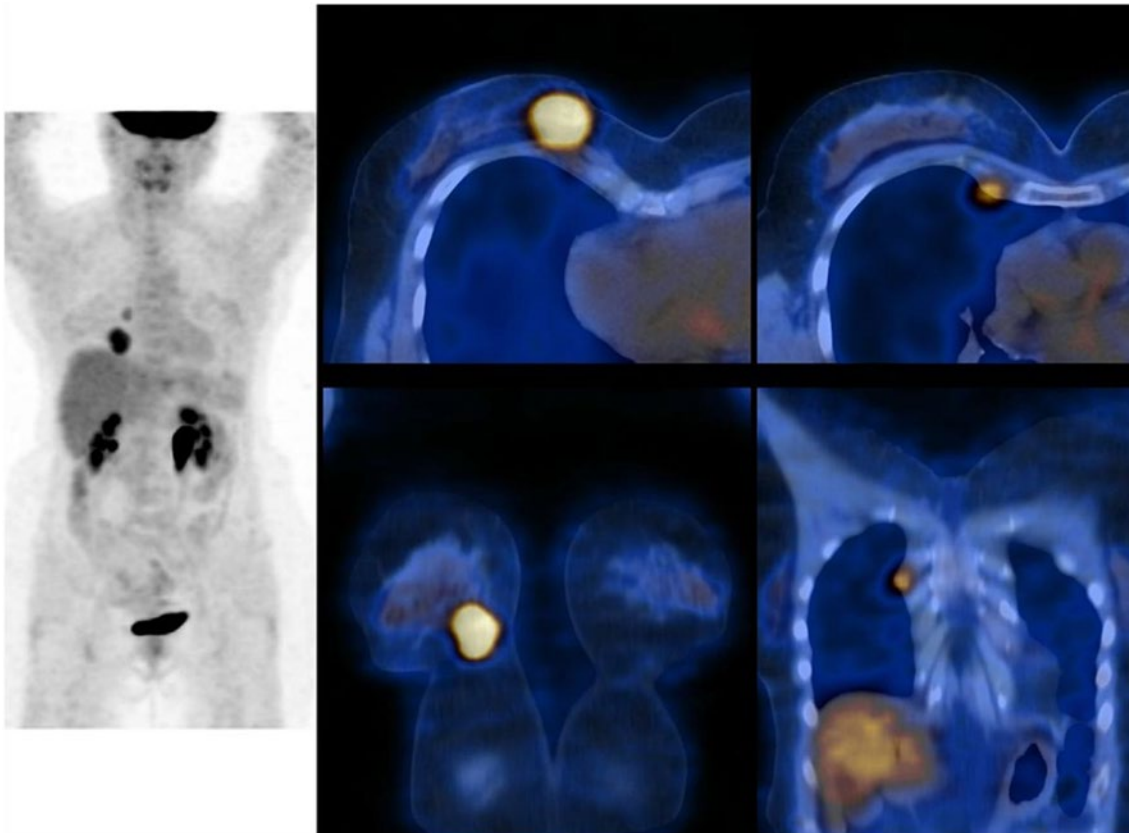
Invasive ductal carcinoma of right breast initially classified as T4cN0M0 (on basis of clinical examination, mammography, breast MRI, breast and axilla ultrasound, chest and abdominal CT scans, and bone scanning) in 63-y-old woman. PET/CT shows large breast tumor infiltrating skin and pectoral muscle (T4c) and depicts FDG-avid internal mammary node (final classification: T4cN2bM0). *Reprinted with permission from Groheux D J et al. JNM February 2016, 57 (Supplement 1) 17S-26S.*
